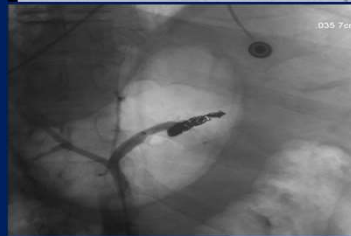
(Top) Angiography showing multifocal areas of hypo-vascularity but no contrast extravasation. (Middle) Angiography after coil embolization of the proximal splenic artery. (Bottom) Axial view of CT scan showing splenic infarct and pancreatic necrosis
